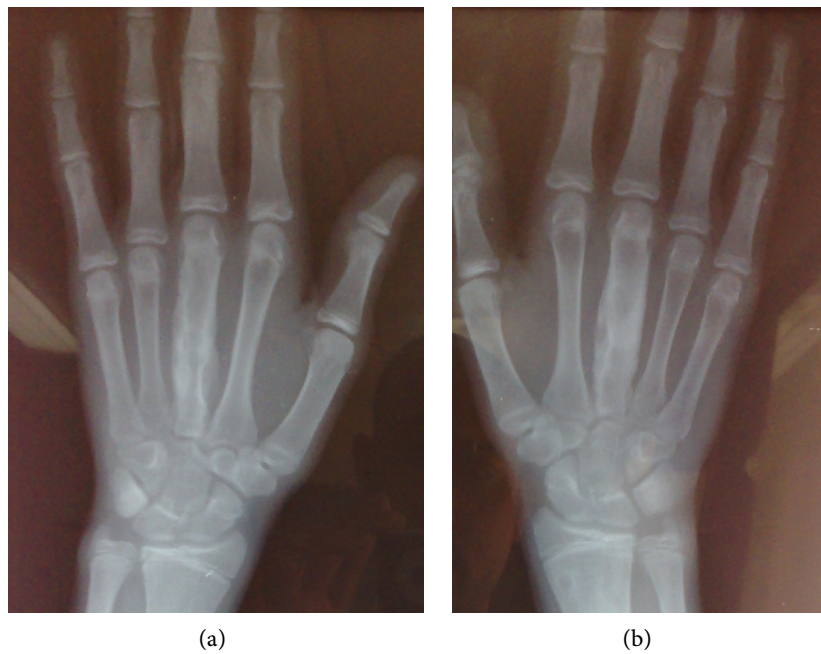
(a) and (b): plain X-ray, anteroposterior view of right and left hand showing diaphyseal osteosclerotic and lytic lesions involving the third metacarpal bones diaphysis on both hands.
